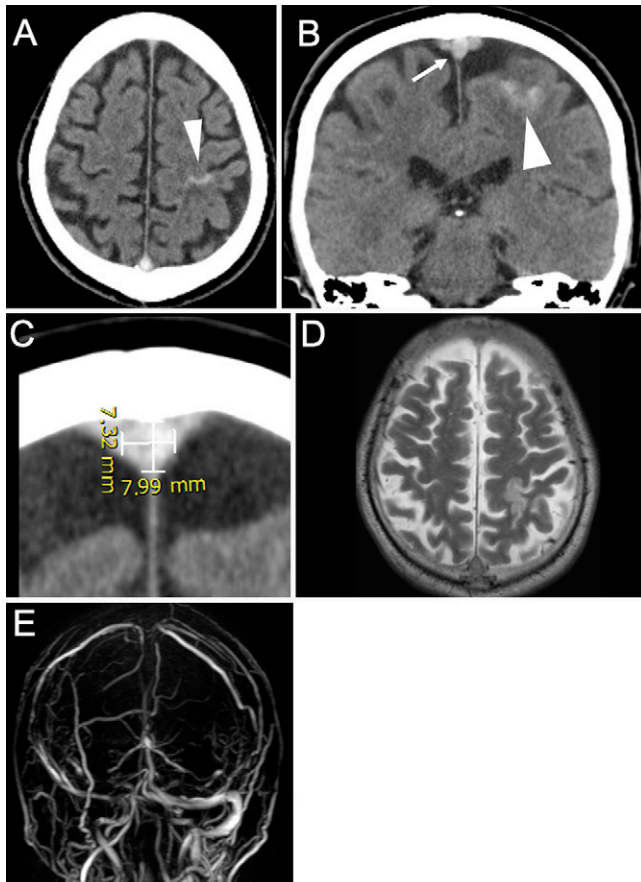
Admission axial (A) and coronal (B) CT images showing subarachnoid hemorrhage (SAH) in the left central sulcus (arrowheads) and a high-density area in the SSS (arrow), measuring 7.32×7.99 mm² (C). Admission T2-weighted MRI demonstrating a high-intensity area in the left primary motor and sensory cortex (D). Magnetic resonance venography, lateral view, demonstrating occlusion of the SSS, right TS, and SS (E).
